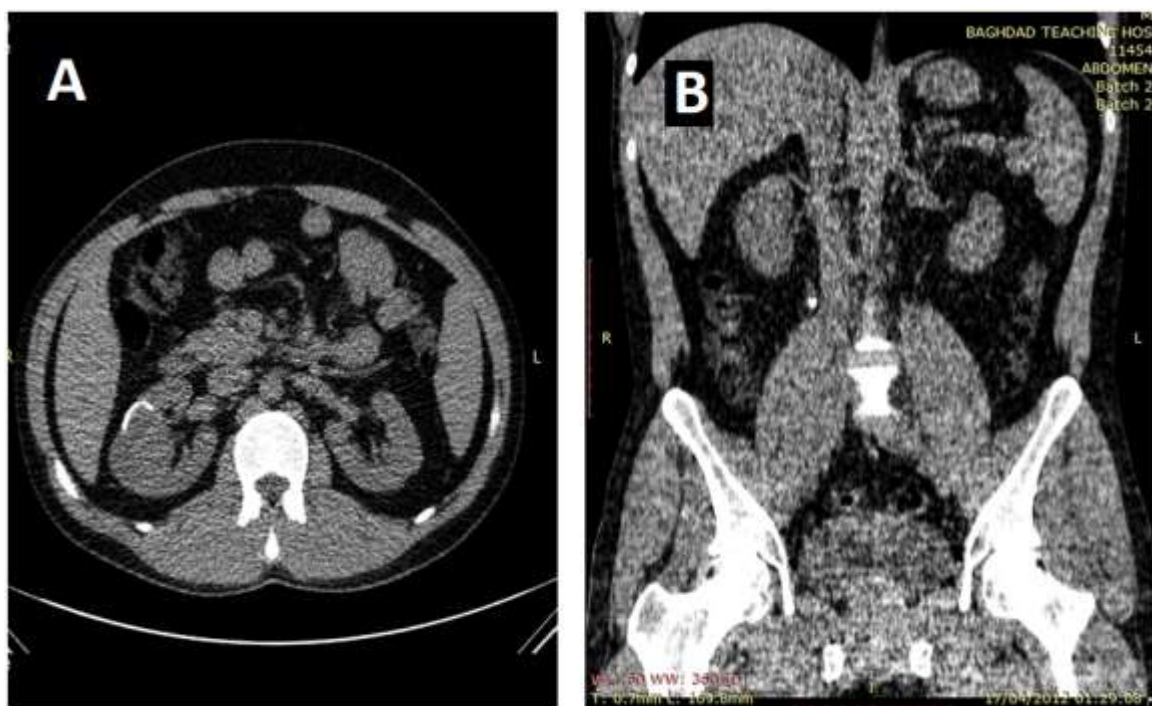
low dose contrast enhanced CT urography in 30 years old patient with right loin pain radiating to the groin and haematuria ; A: native phase :incidental finding of a midcortical well defined soft tissue mass in RT. kidney with arc like calcification . B: The same patient , native phase , coronal section showing mid ureteric stone and mild hydroureter
